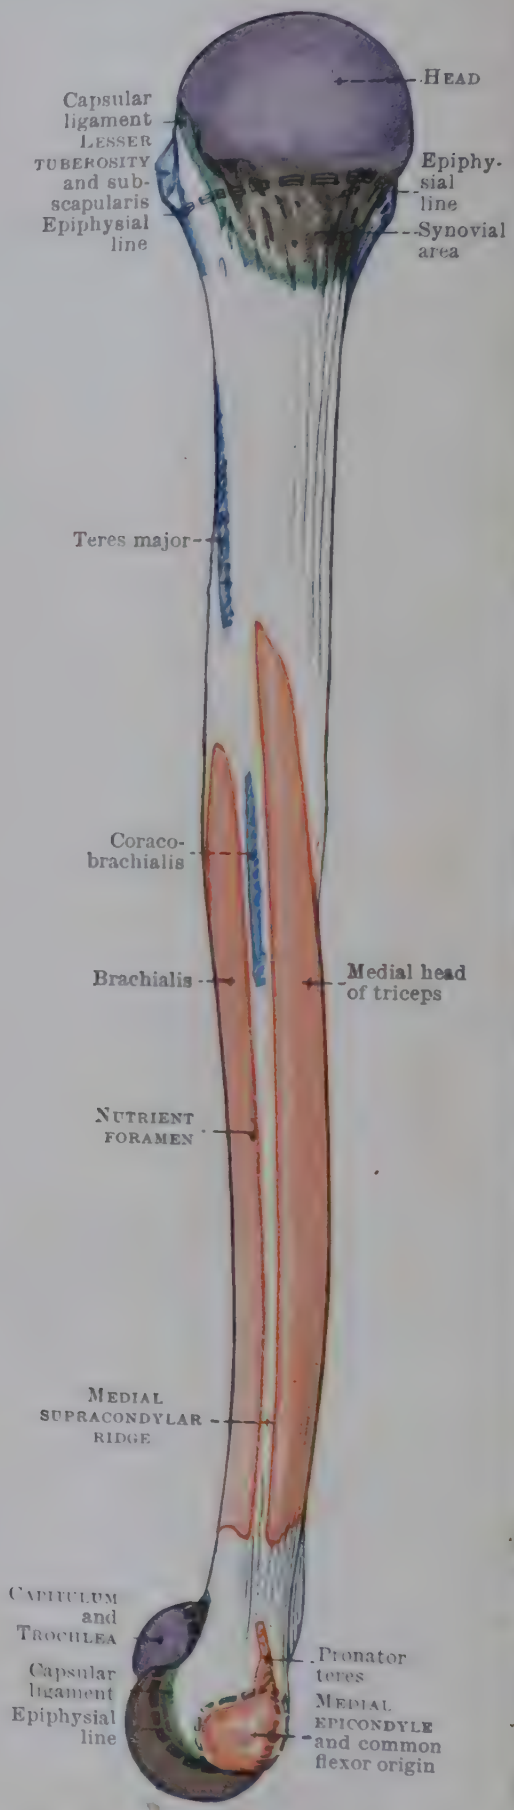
MEDIAL ASPECT OF RIGHT HUMERUS.
